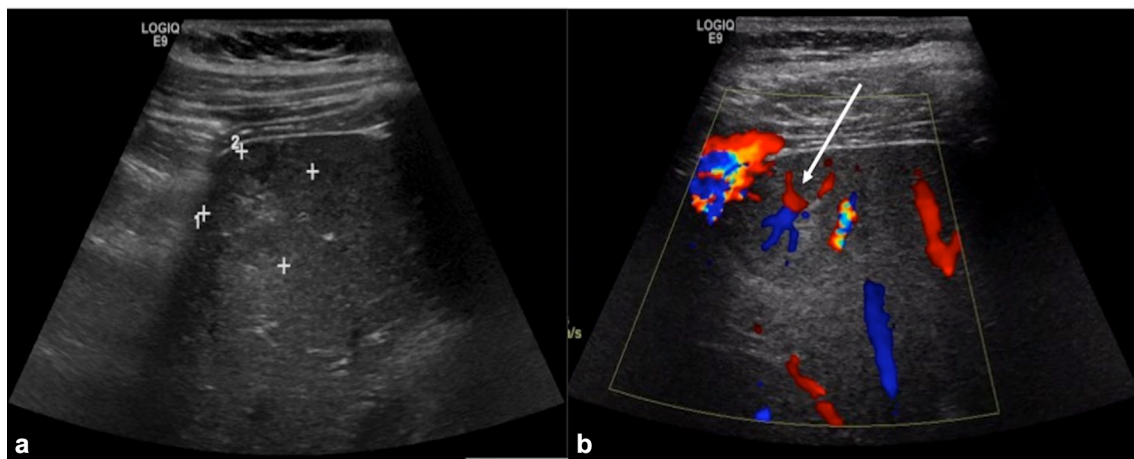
A 31-year-old woman with elevated liver enzymes in the setting of oral contraceptive use. a Grayscale ultrasound image demonstrates a subtle isoechoic lesion (calipers) with hyperechoic
